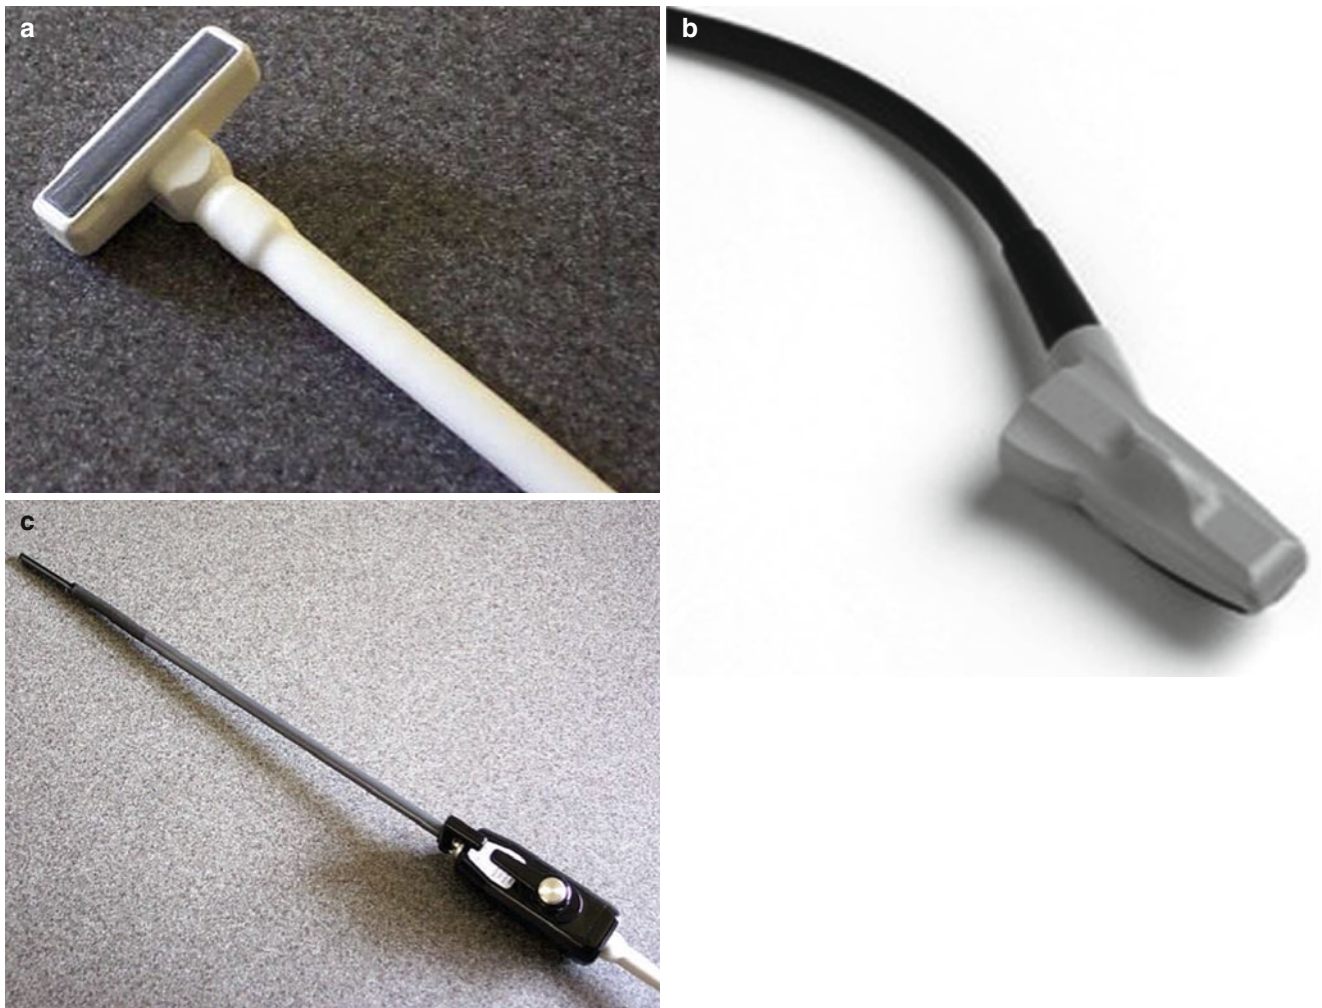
Ultrasound transducers designed for use in surgery: (a) T-style linear probe, (b) I-style convex probe, and (c) laparoscopic probe
